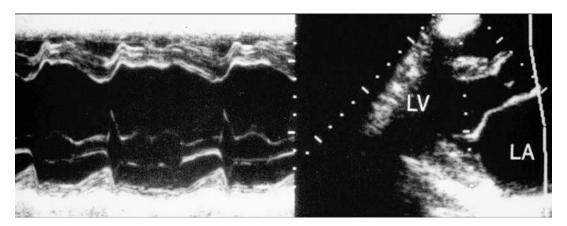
M-mode and two-dimensional echocardiography from the same patient with endomyocardial fibrosis as in Fig. 24.31 demonstrating the abnormal diastolic left ventricular filling. During diastole, the left ventricle fills
